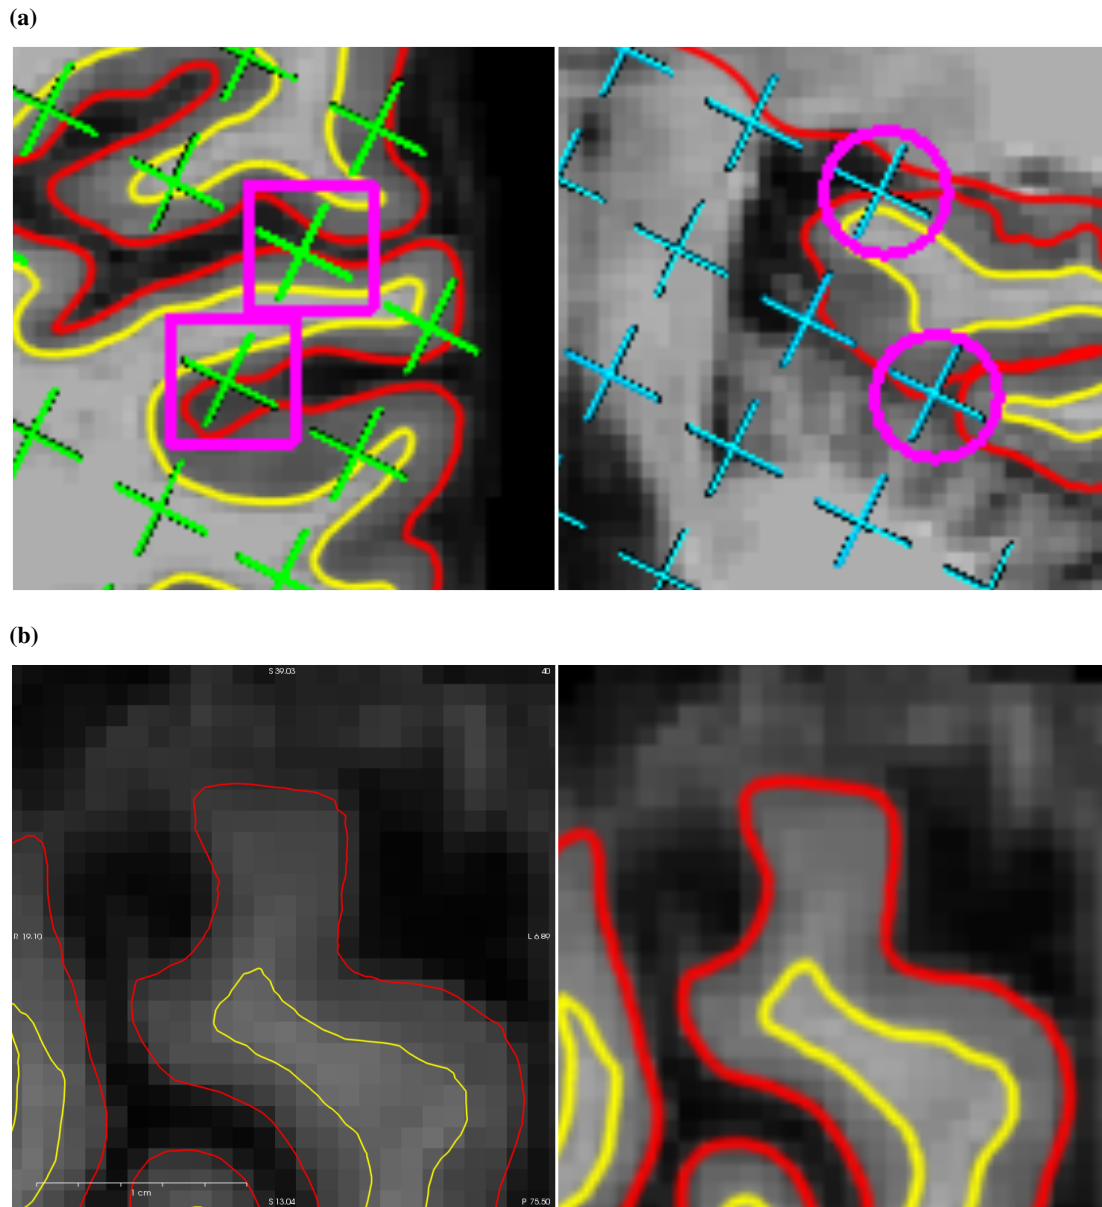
(a) Test points (inside pink rectangles on the left or circles on the right) hitting on thick pial surface boundaries (red) are difficult to tell whether the test points should be included or excluded. (b) The thickness of the pial surface boundary lines (red) becomes thinner when the MR image is enlarged (six times in this case) in FREESURFER before screenshot is taken (left) in comparison with red boundary lines in original scale (right).
